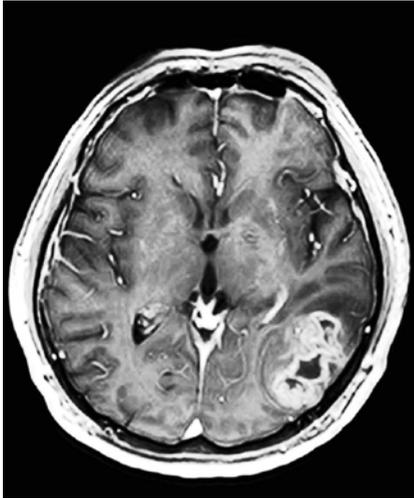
MRI brain with contrast axial cut. Showing left parietooccipital intraxial space occupying lesion, oblong in shape with central necrosis, heterogeneous enhancement and minimal brain oedema.
